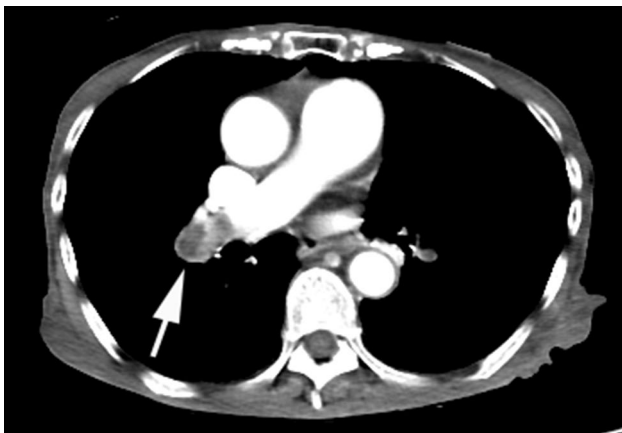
80-year-old woman with abdominal cancer. Axial CT chest demonstrates enhancing filling defects in the right pulmonary artery (arrow), consistent with tumor emboli
